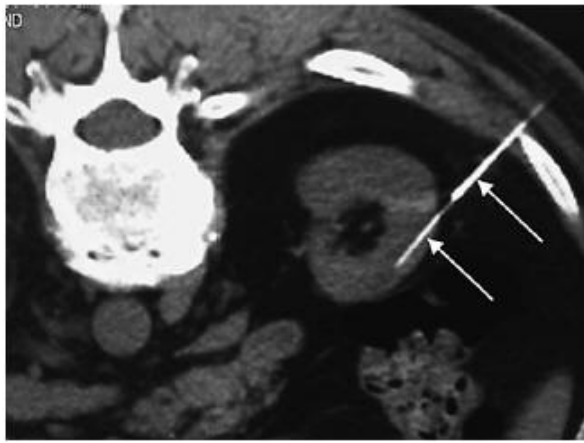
Percutaneous CT-guided REACT injection. Patient in prone position in CT scanner. Insertion of outer guide and inner injection needles into the renal cortex in subcapsular location (arrows). CT allows real-time evaluation of needle location, REACT deposit, and bleeding complications. REACT, renal autologous cell therapy; CT, computed tomography.
